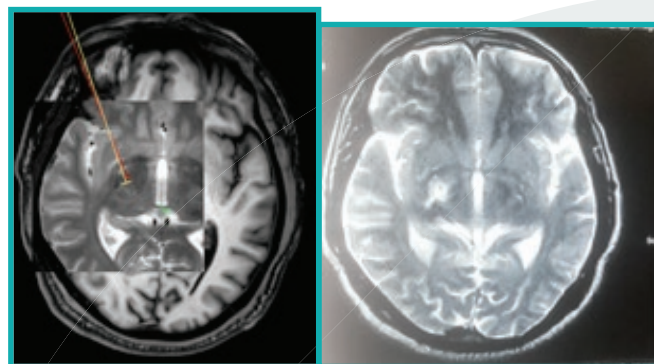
A) Preoperative targeting of Right GPi in T1/T2 image fusion MRI and B) Postoperative T2W MRI of same patient showing Right pallidotomy with perilesional edema
